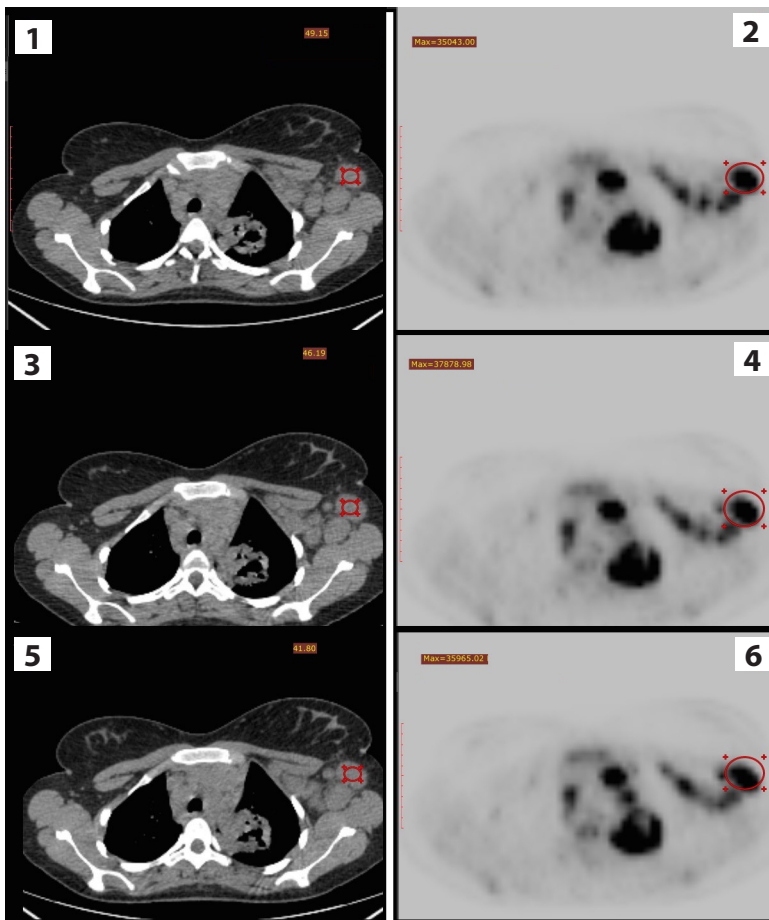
This image presents the method of assessing mean density (in HU) of a malignant left axillary lymph node before CTx treatment. The ROI measurement was put on the central part of the lymph node (image 3). It should cover at least half of the area of the lymph node on the axial scan with the highest SUV_{max} value (image 4). Due to the risk of slight CT-PET image misalignment, density measurements were performed on 2 adjacent CT axial scans as well (images 1–2 and 5–6). The final HU value was an arithmetic mean of the 3 previous measurements
